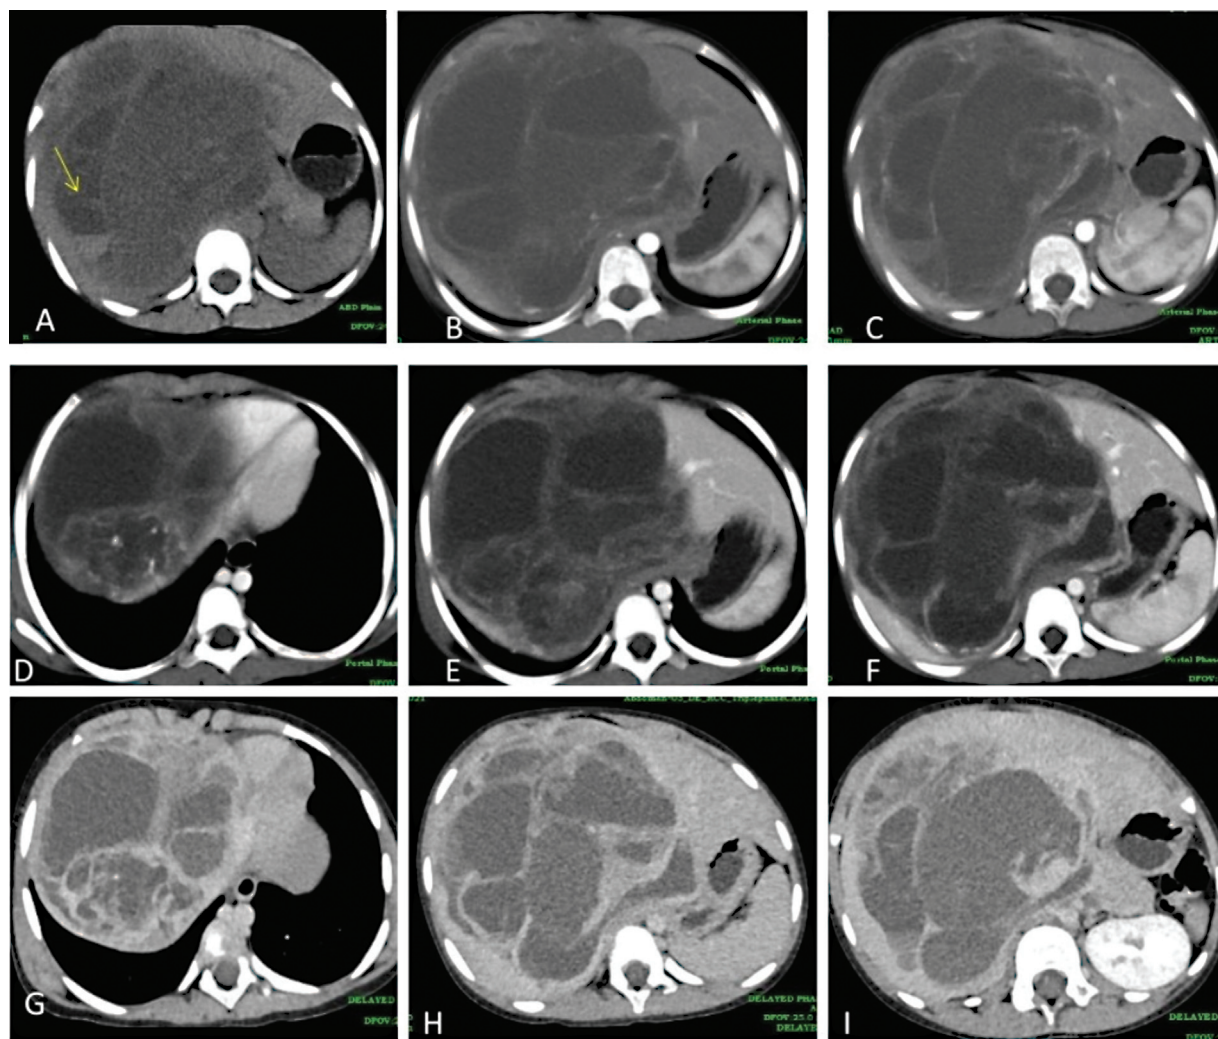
Plain (A) and dual-phase contrast-enhanced computed tomography (CECT) arterial phase (B, C), venous phase (D–F), and delayed phase (G–I) show multiseptated cystic lesion with varying density contents, high density areas with fluid–fluid level suggesting hemorrhage (arrow). Delayed phase (G–I) showing moderately enhancing thick septae and solid components.
